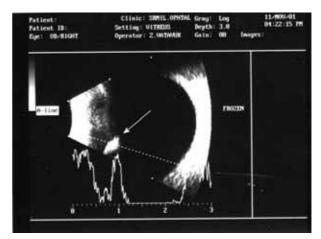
Ultrasound scan clearly showing an intraocular foreign body (arrow) located in the anterior part of the vitreous body.
